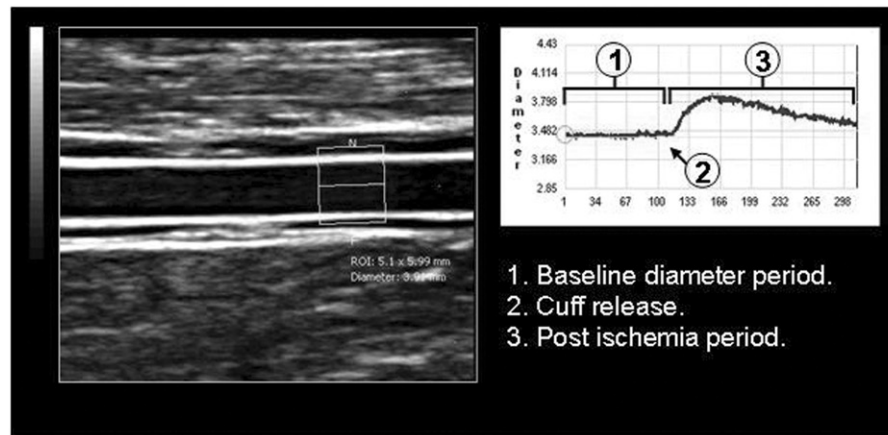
B-mode ultrasound of brachial artery flow-mediated dilatation (FMD). This figure shows a longitudinal image of the brachial artery. A diastolic image is recorded in each heartbeat. For off-line image analyses, a region of interest (white box) is selected for continuous automated measurement of brachial artery diameter. On the right, the brachial diameters (y-axis) are shown for each recorded image (x-axis). The average baseline diameter can be calculated from the recorded frames prior to cuff inflation. The maximum diameter is measured after cuff release.
